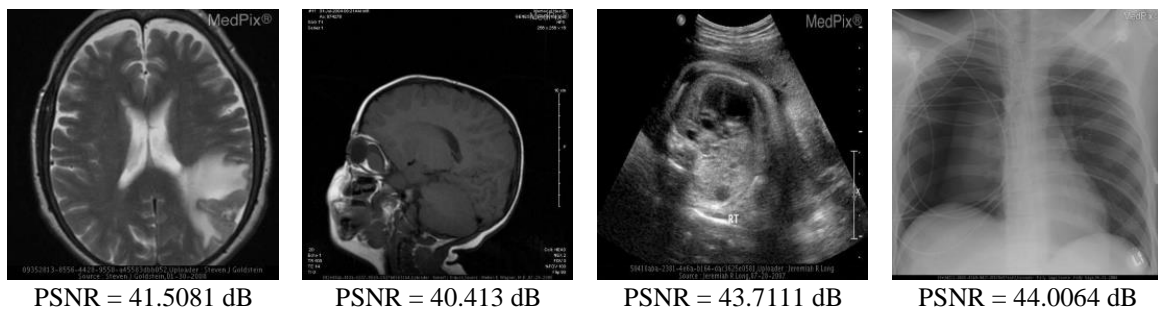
Watermarked image and PSNR of each modality medical images (CT, MRI, US, X-Ray)
